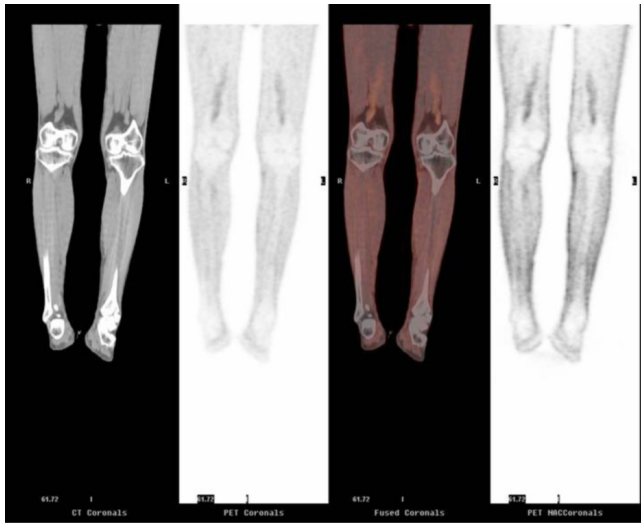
Subsequent coregistered ¹⁸FDG PET CT coronal image post excision and radiotherapy shows no residual areas of abnormal ¹⁸FDG uptake consistent with good treatment response.
